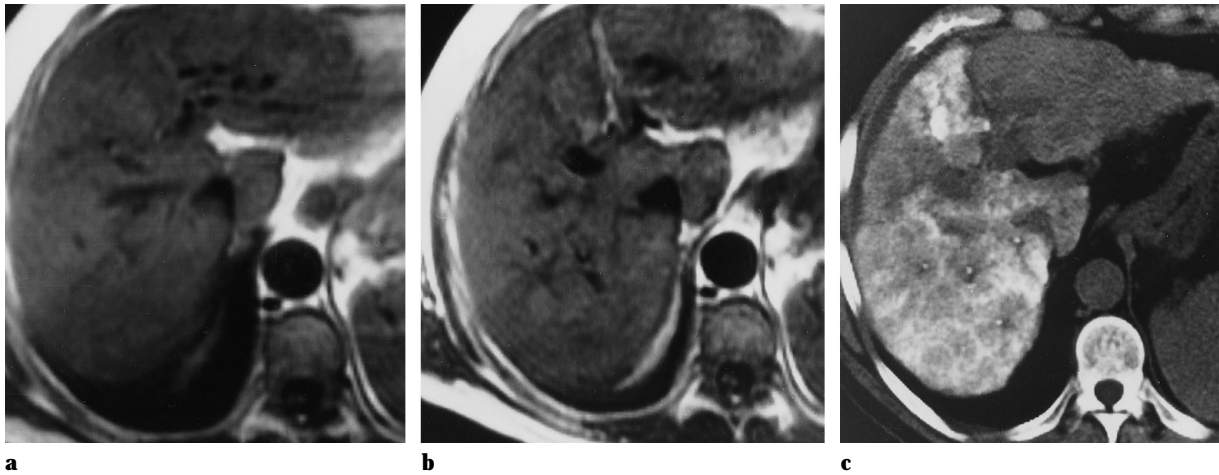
The T1W images before (a) and 1 day after TACE (b) show no difference in the signal intensity of liver parenchyma. c CT scan performed 1 day after TACE shows lipiodol distribution in the liver
